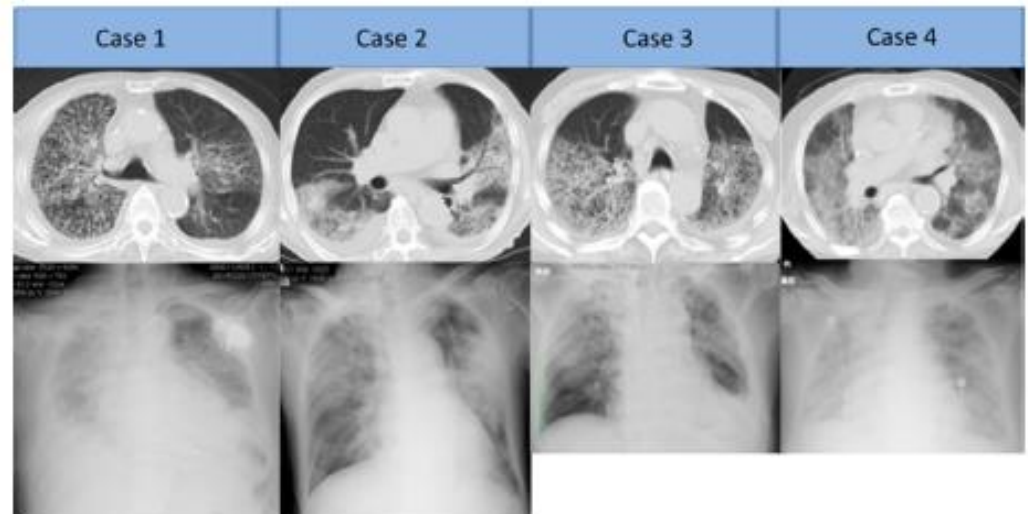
Chest computed tomography and routine radiography early after symptom onset.
